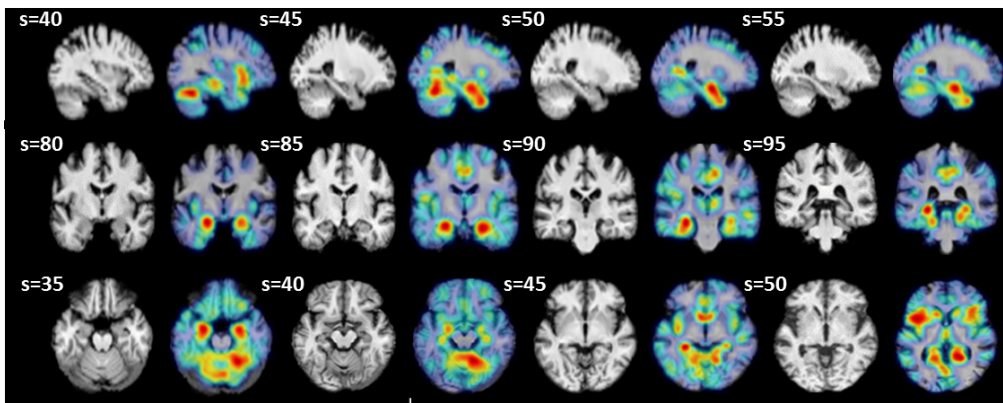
MRI slices selection of NC subject (the subject is 86 years old with an MMSE equal to 30).
